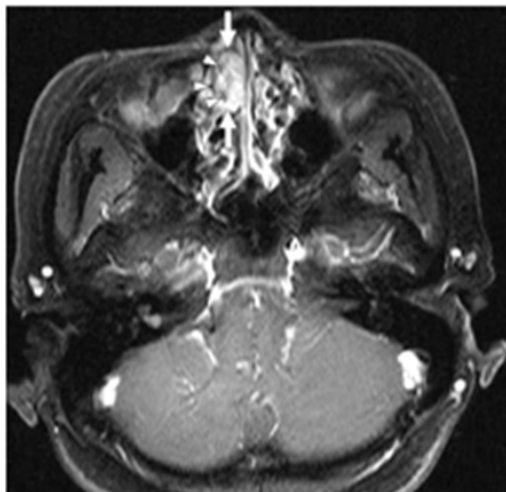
MRI T1W1 Lobular intensely enhancing mass (arrow). Capillary hemangioma of nasal septum (right side).
